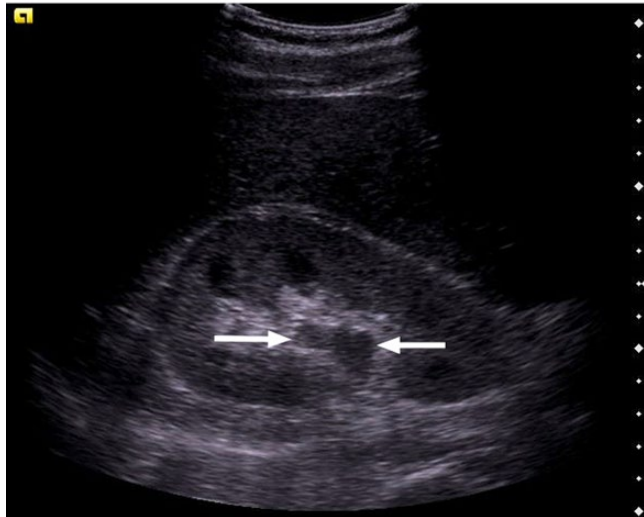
(a, b) Two examples of mild hydronephrosis, which can easily be overlooked or mistaken for renal vessels, requiring confirmation in real time or using colour-flow Doppler (see panel (c) and Video 15.3). Figures © A. J. Dean.
